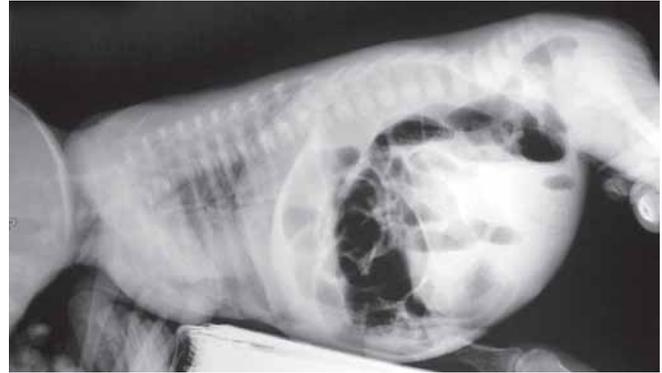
Prone cross table lateral X-ray in HD showing dilated sigmoid but relatively collapsed rectum
